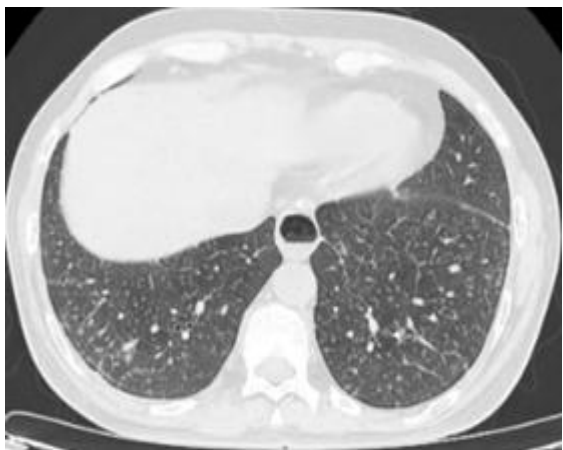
HRCT thorax showing interstitial septal thickening and bilateral nodularity.
